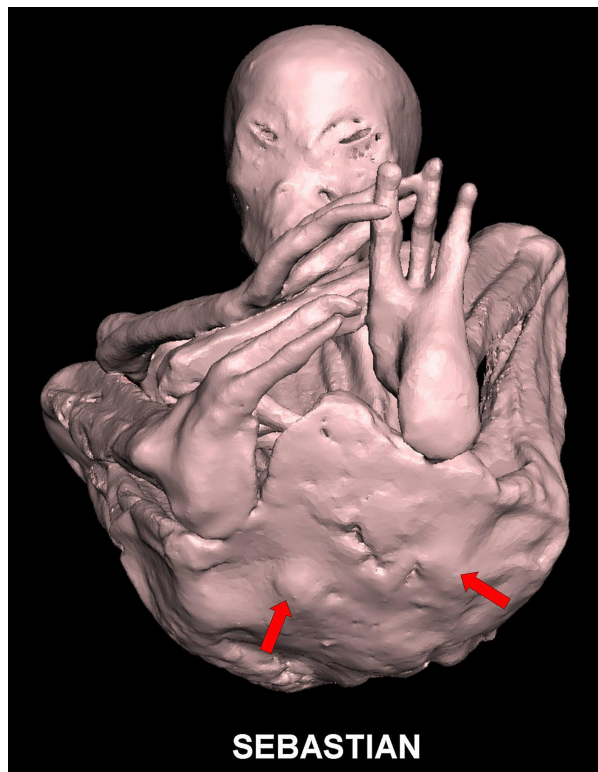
3D CT showing flat triangular shaped perineum with lack of buttock prominences. Position of ischial tuberosities are marked. *(red arrows)*
